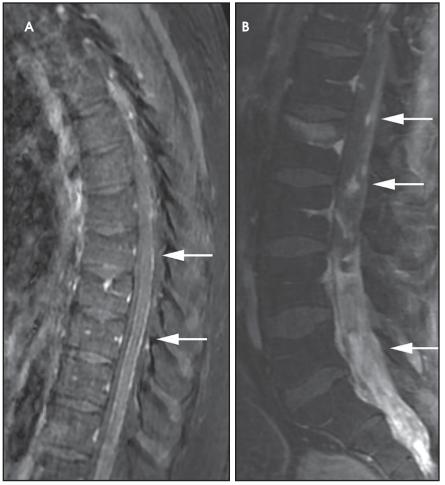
Sagittal T1-weighted postcontrast MR images with fat suppression of the thoracic (A) and lumbar (B) spine demonstrate marked leptomeningeal carcinomatosis (arrows) with involvement of multiple bilateral foraminal and intrathecal nerve roots.
